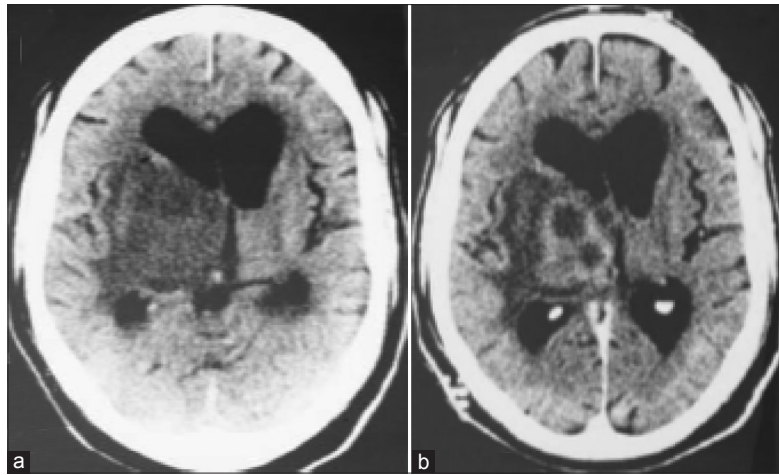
(a) Non-contrast CT scan showing an extensive hypodense lesion in the area of the right basal ganglia with mass effect. (b) Contrast enhancement shows multiple ring enhancing lesions within the hypodense mass. This was a case of cerebral toxoplasmosis as the patient recovered completely with drug treatment for this condition
